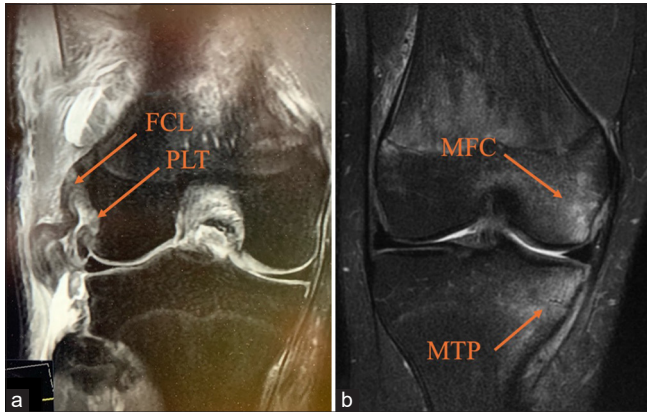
(a) A coronal magnetic resonance imaging (MRI) of the right knee displays fibular collateral ligament (FCL) attenuation and a popliteus tendon (PLT) avulsion, marked by arrows. (b) Acute posterolateral corner injuries frequently present with anteromedial bone bruising, observed in up to 55% of cases. This coronal MRI of the right knee shows increased signal intensity in the medial femoral condyle (MFC) and medial tibial plateau (MTP).
